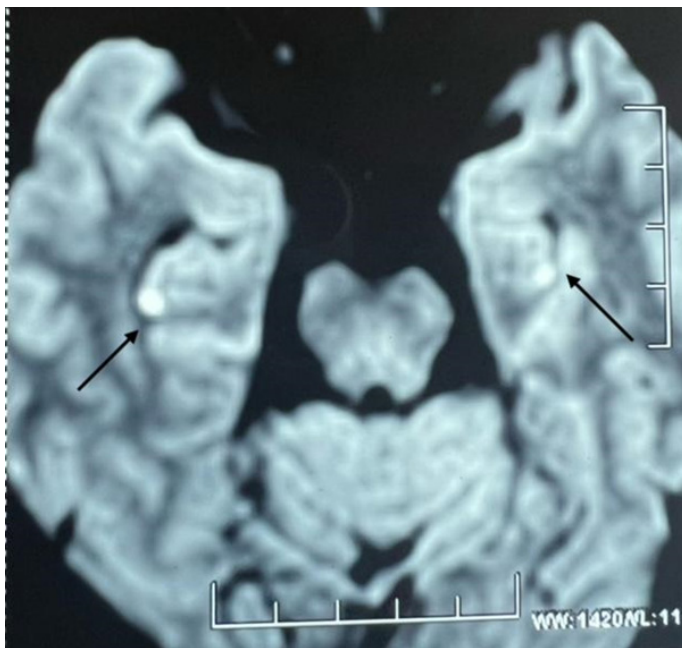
Axial MRI brain diffusion weighted image showing dot like hyperintensity in CA1 region of both hippocampi
